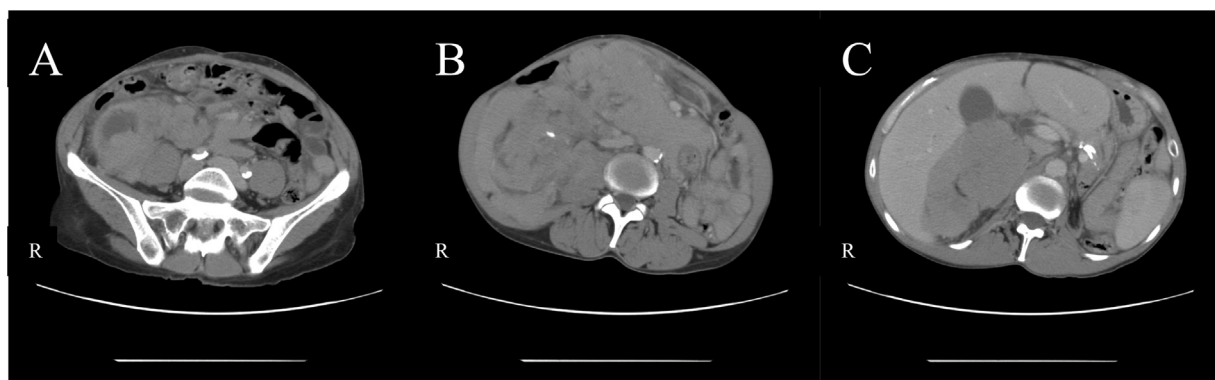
A contrast enhanced CT scan of the patient's abdomen at the time of presentation. The mass was found to measure $13 \times 13 \times 19$ cm on the right side of the abdomen. (A) Lower Retroperitoneal Mass: There is demonstrated involvement of a failed right-sided iliac kidney allograft. This appears grossly expanded and distorted. There are cystic regions within the mass that are most likely related to necrosis. (B) Mid Retroperitoneal Mass: The mass is causing soft tissue abnormalities within the retroperitoneum at the level of the duodenum and appears to involve the right retroperitoneal renal allograft. (C) Upper Retroperitoneal Mass: The liver is homogenous in appearance, with mild intra- and extrahepatic biliary duct dilation. There is mass effect on the pancreas with prominence of the pancreatic duct. Native right kidney is present, atrophic and does not appear to be involved by the mass.
